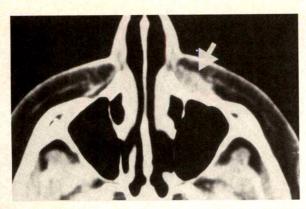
Figure (Chestler, Dortzbach, and Kronish). Axial computed tomography section through maxillary sinus at level of infraorbital foramen. Arrow points to recurrent rhabdomyosarcoma on anterior maxillary wall.
